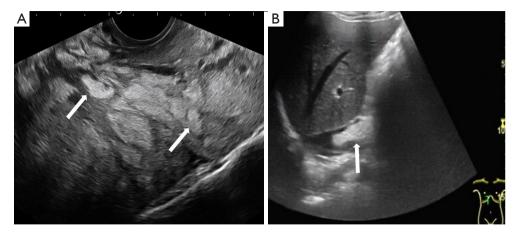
Ultrasonoscopy. (A) Multiple hyperechoic nodules in the uterine cavity on transvaginal ultrasound. The arrows point to the hyperechoic nodule. (B) Abdominal ultrasound showing a hyperechoic mass within the IVC. The arrow points to the hyperechoic mass. IVC, inferior vena cava.
